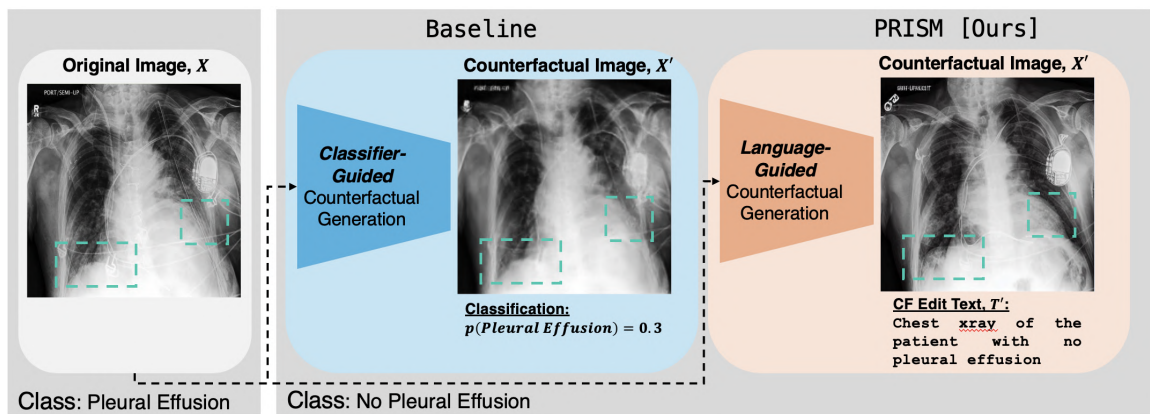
Counterfactual (CF) explanations for a subject with ‘Pleural Effusion’. (a) Original chest radiograph of subject; (b) Classifier-guided CF image fails to show changes in the diseased area and determined the CF image is healthy. The classifier is biased and associates the disease with the medical device; (c) PRISM modifies the area of disease pathology, leaving the devices (e.g. pacemaker) unchanged.
